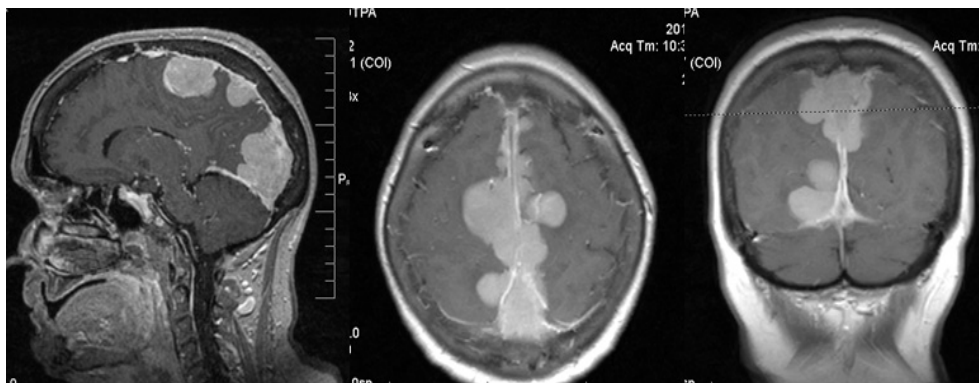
(Case 3) T1-weighted images with contrast showing a superior sagittal sinus meningiomatosis
